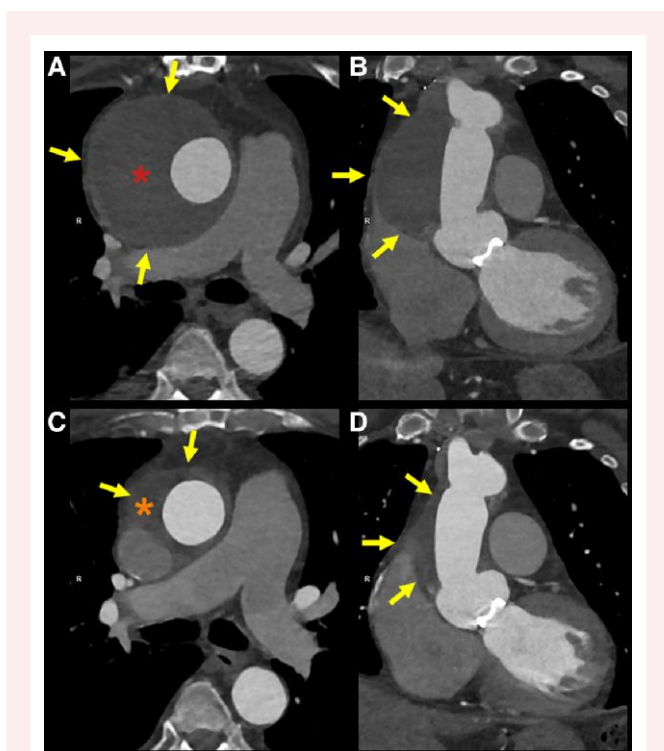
Axial (A, C) and coronal (B, D) multiplanar reconstructions of the pseudoaneurysm at the index CTA (A, B) and 2 years after intervention (C, D) showed reduction of the AAP size without detectable leaks.
